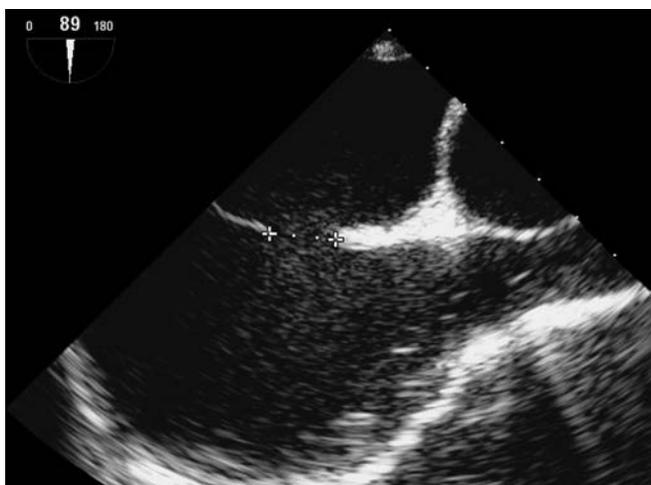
Transesophageal echocardiogram of interatrial septum with measured atrial septal defect.
